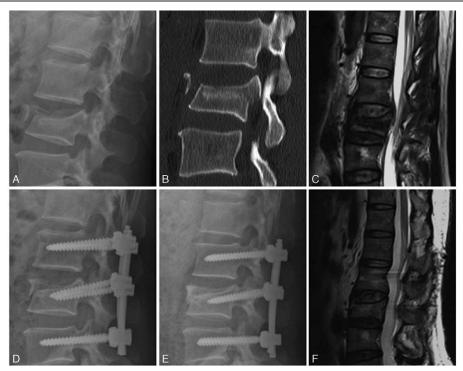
A 46-year-old man, with L2 burst fracture. Preoperative lateral radiograph (A) and CT (B) showed L2 vertebral fracture with a fragment in the vertebral anterior edge. Preoperative MRI (C) showed Pfirrmann grade 1 of L1-L2 disc and Pfirrmann grade 2 of L2-L3 disc. X radiograph immediately after surgery (D) revealed the teardrop fragment was not reduced completely. After follow-up for 2 years, X radiograph (E) showed no healing of L2 fracture. MRI (F) showed Pfirrmann grade 3 of L1-L2 disc and Pfirrmann grade 3 of L1-L2 disc and Pfirrmann grade 3 of L2-L3 disc. CT=computerized tomography, MRI=magnetic resonance imaging.
